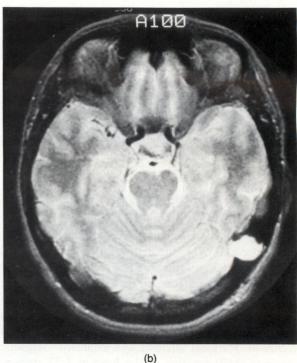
(a) T1-weighted coronal image (TR/TE = 700/20) shows low signal intensity mass lesion in the left temporal bone with its epicenter in the diploic space (solid arrow). This lesion compresses the left transverse sinus with complete obstruction, as evidenced by mass compression and the lack of flow void. Compare normal flow void on the right (arrowhead). (b) T2-weighted (TR/TE = 2800/80) axial image shows the tumor with high signal intensity.
